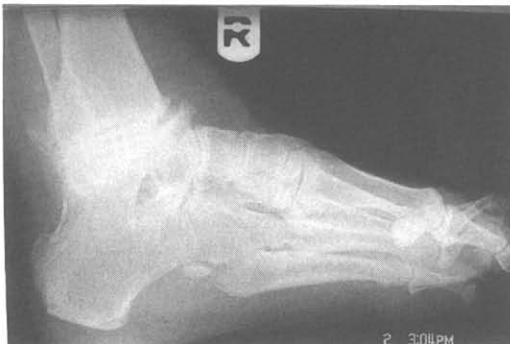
Radiograph shows tibial talar exostosis, which causes compression and anterior tarsal tunnel syndrome.
